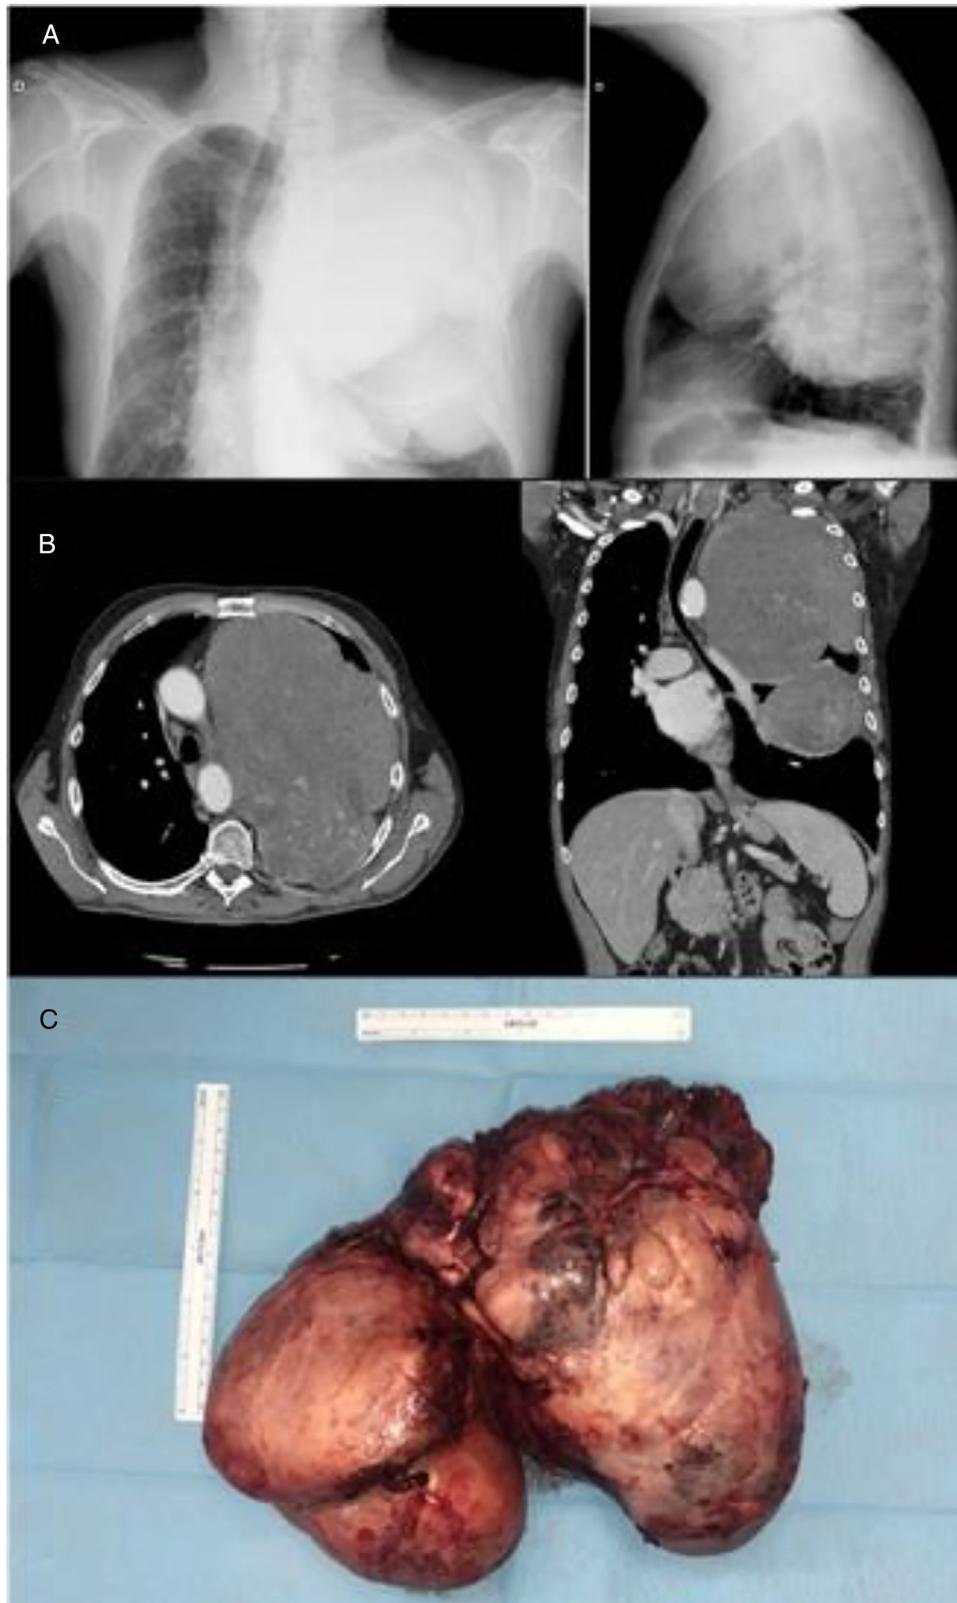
(A) Posteroanterior and lateral chest X-ray. (B) Chest CT with intravenous contrast, showing a large pleural mass with shift of mediastinal structures. (C) Tumor mass after surgical removal.
